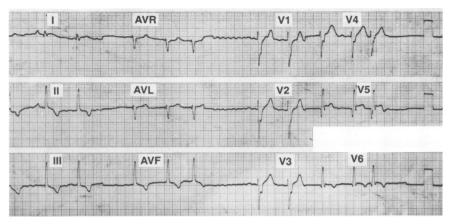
Echocardiogram showing atrial fibrillation and Q waves in Leads I, aVL, and V_4 - V_6 , suggesting lateral infarction.
